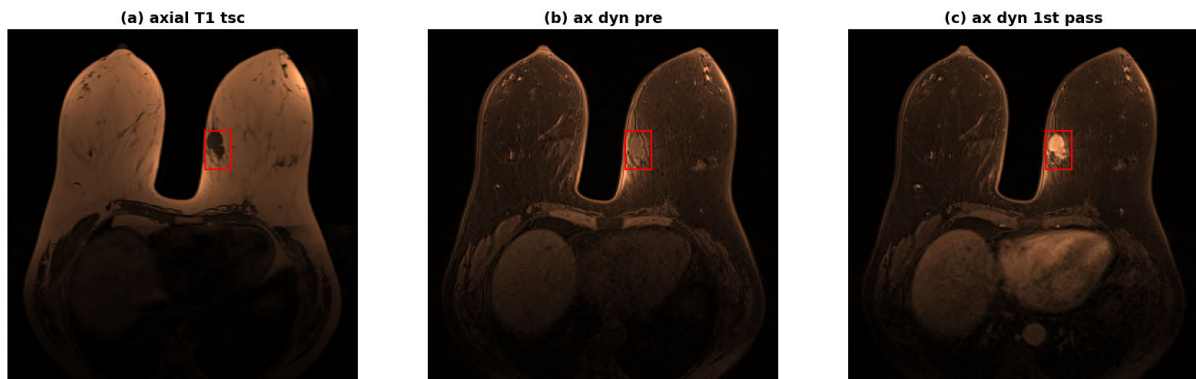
MRI modalities from the publicly available Duke database [7] showing images of patient 112, with a bounding box marking the suspicious area.
